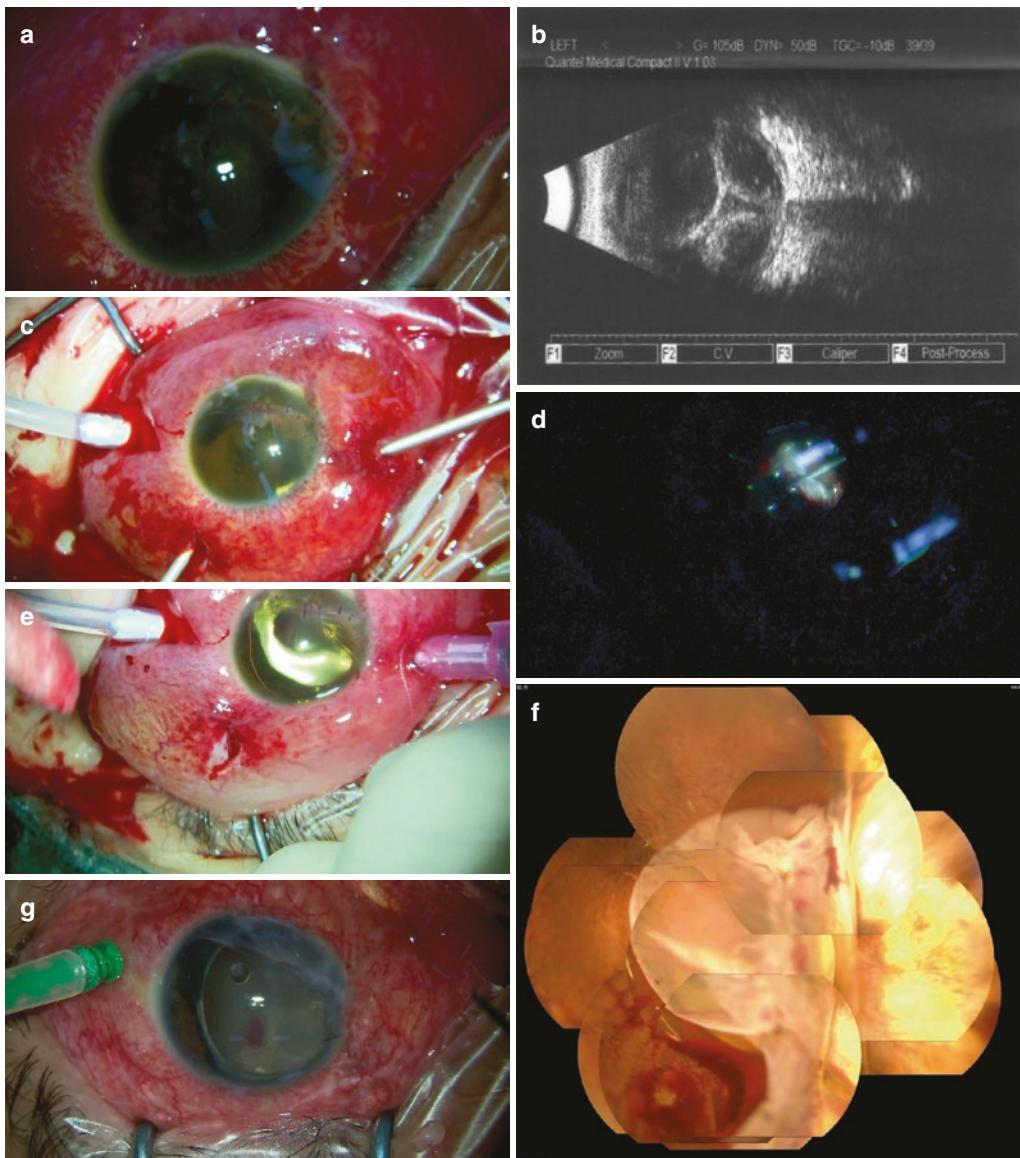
(a) A 22-year-old male, the left eyeball was injured by piece of glass during basketball game; suture was completed locally. (b) Ultrasonography showing bulous choroidal detachments. (c) Vitrectomy for the first time (13-1-17): three-tunnel vitrectomy. (d) Clearance of vitreous hemorrhage and reposition of retina. (e) Silicone oil tamponade. (f) First day after surgery, patient complained light perception. (g) Supplementary silicone oil injection repeated for three times through limbal incision, IOP stable
